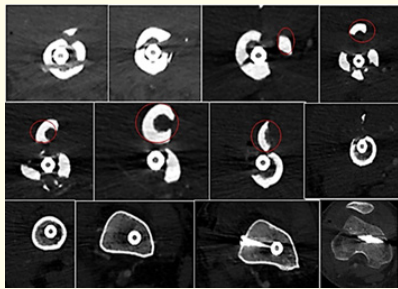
CT-scan showing dislocation and fragment size.
